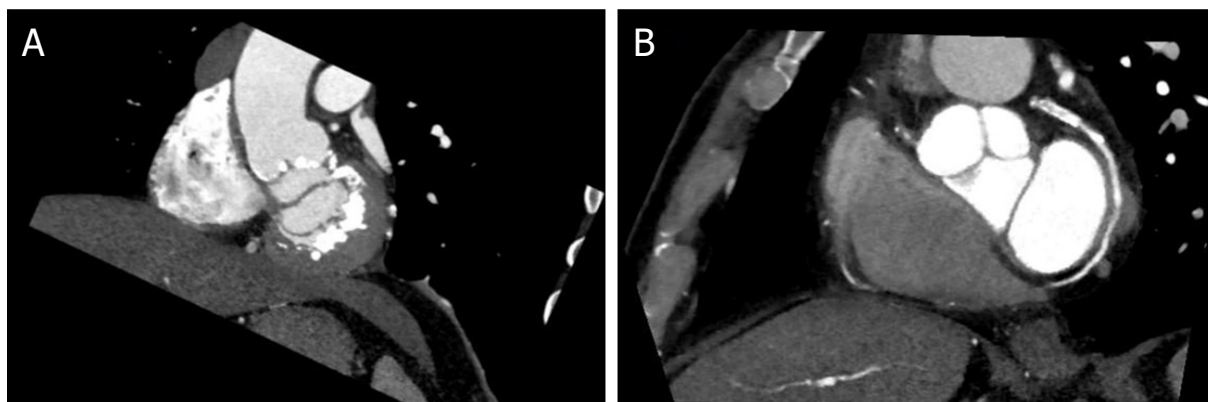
(A) Cardiac CT short-axis view of the mitral valve at the level of the mitral annulus, showing annular calcification; and (B) short axis view at the level of the atrioventricular groove showing the course of the left circumflex artery
